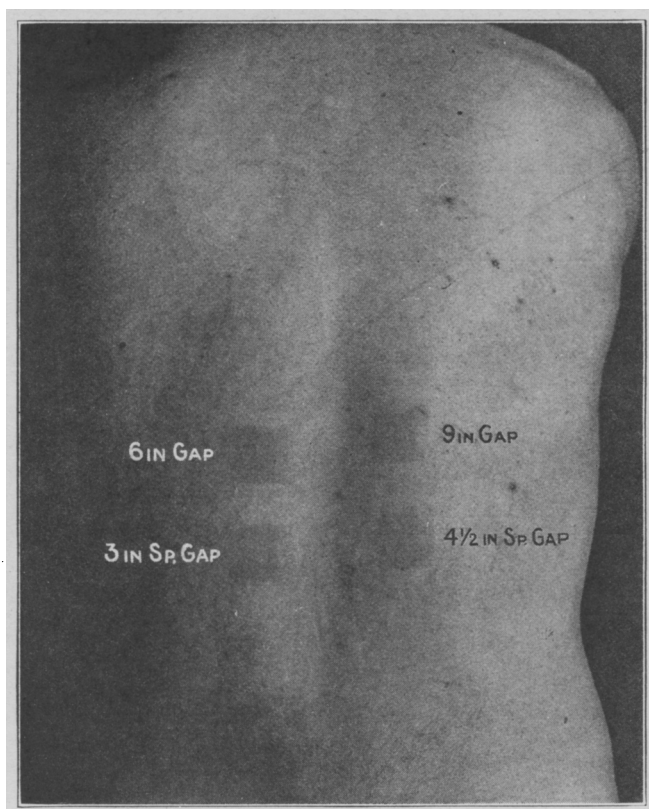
Four areas of patient's back treated with the roentgen ray.
